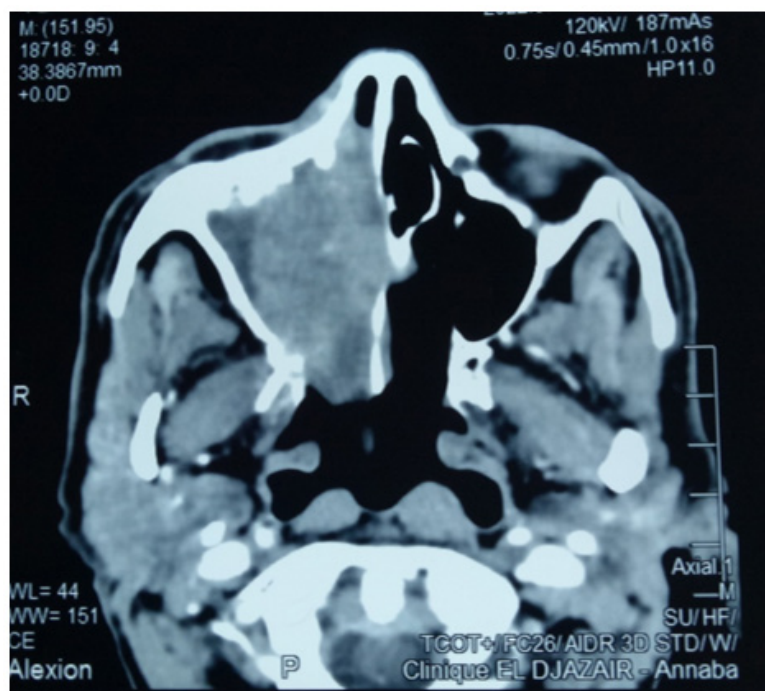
Axial CT scan showing an isodense, aggressive tumor of the right maxillary sinus, displacing the lateral nasal wall.
